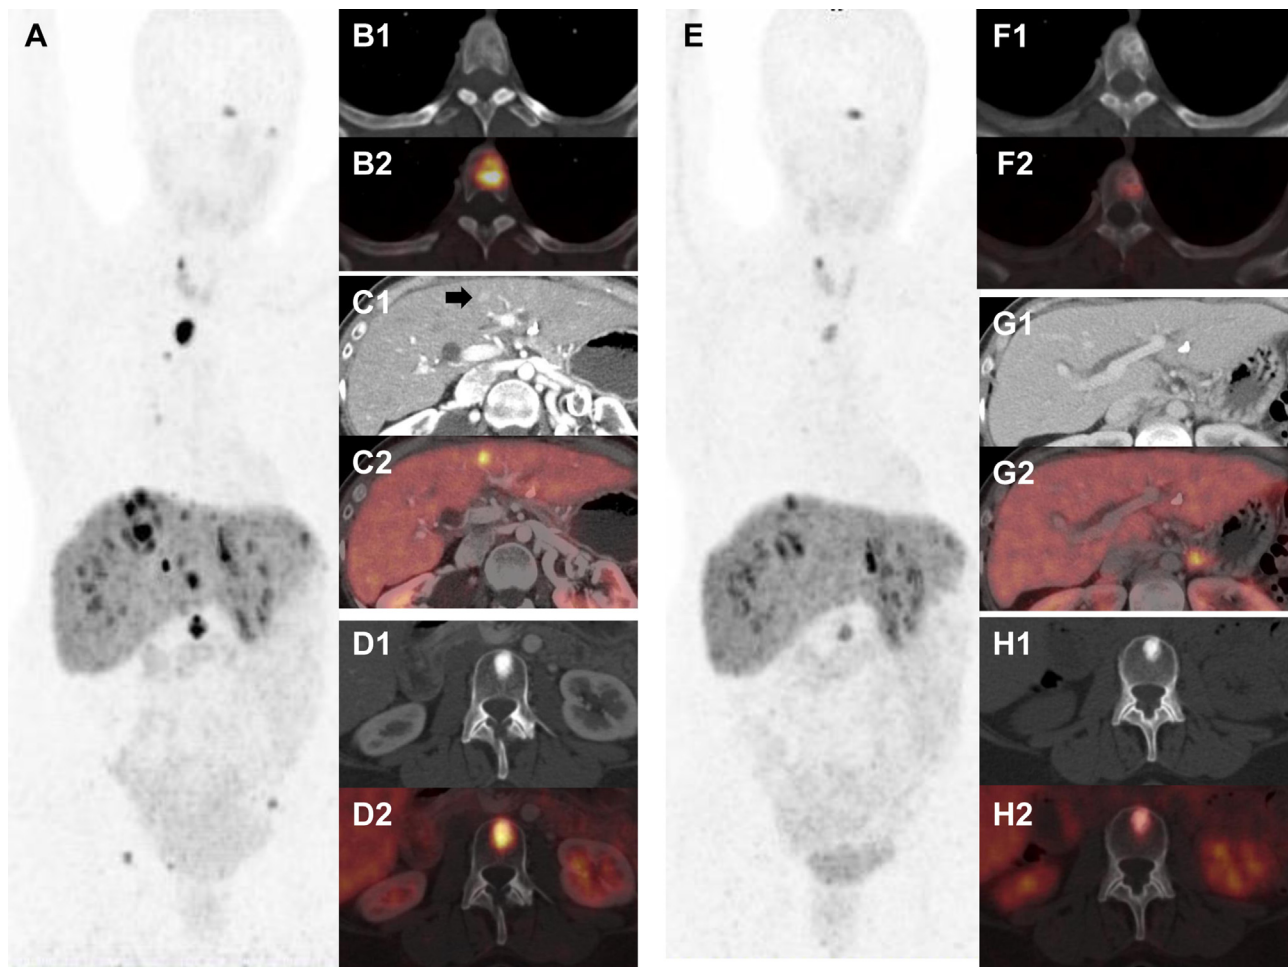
A 67-year-old lady with poorly differentiated functioning neuroendocrine neoplasm (NEN) of the pancreatic tail with metastases to liver, spleen, and bones was referred with progressive disease after a progression-free interval of 19 months status post 3 cycles of peptide receptor radionuclide therapy (PRRT). The fourth PRRT cycle, performed in combination with capecitabine, resulted in partial remission (PR) of disease. (A-D) ^{68}Ga -DOTATOC PET/CT before the fourth PRRT; (E-H) ^{68}Ga -DOTATOC PET/CT after fourth PRRT cycle; (A and E) maximum intensity projection (MIP) images; (B1-D1 and F1-H1), transverse slices of CT and (B2-D2 and F2-H2), corresponding transverse PET/CT slices; (B1 and B2) demonstrate a thoracic vertebral body metastasis before therapy, whereas (F1 and F2) are the corresponding images post-therapy demonstrating a therapy response—increasing sclerosis on CT and decrease of the somatostatin receptor (SSTR) expression; (C1 and C2) represent a small SSTR-positive liver metastasis with response to therapy seen after therapy on CT (G1) and PET/CT (G2); (D1 and D2) represent a metastasis in lumbar vertebral body with significant decrease in uptake seen on PET/CT after therapy (H2), whereas no significant change appreciable on CT (H1).
